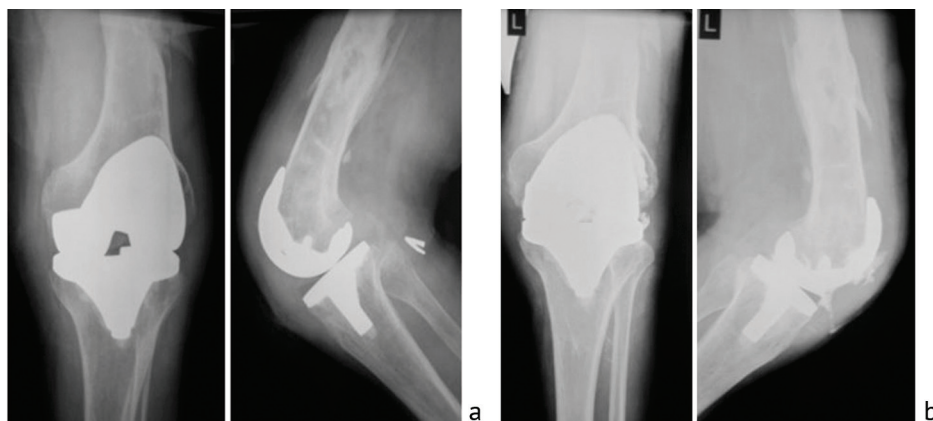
Patient S.: a radiographs after knee joint arthroplasty in 2 projections; b fistulogram
